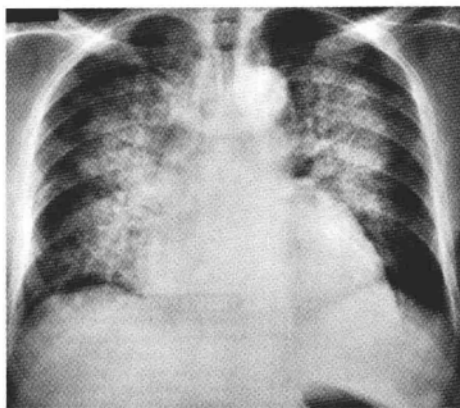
Patient with hydrostatic pulmonary edema due to left-sided heart failure. Chest frontal radiograph demonstrates classic "batwing" distribution of pulmonary edema.
